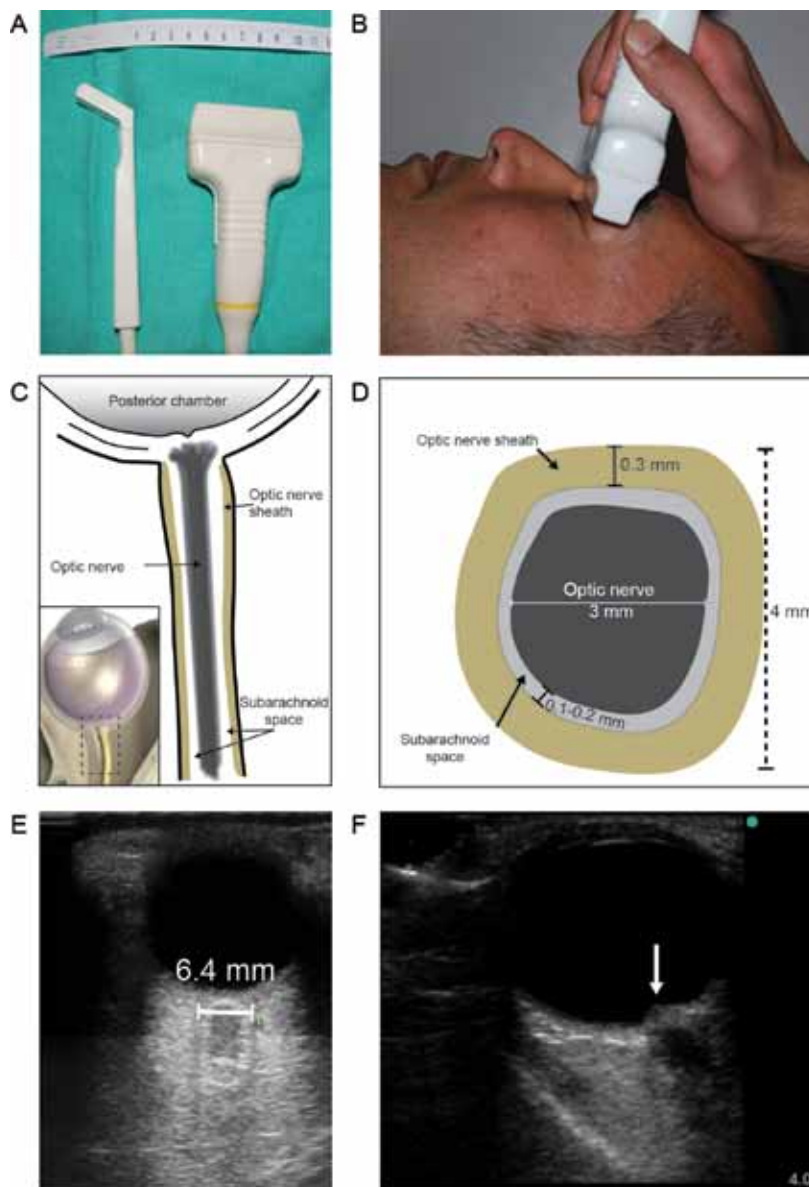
(A) Photo of high-frequency ultrasound (US) probes which can be (B) gently positioned over the eyelid of a closed eye. (C) Aspect of the eye and optic nerve sheath for which the measurement is taken at 3mm from the retina. (D) Cross sectional view of the optic nerve. (E) Dilated optic nerve and (F) papilloedema. (Adapted from Denault et al. 2018 and Soldatos et al. 2009).
